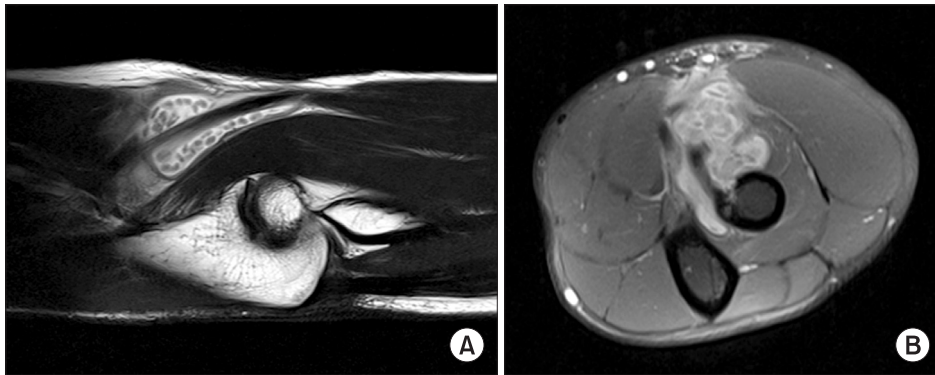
(A) The proton density-weighted sagittal image shows a mass surrounding the biceps tendon that extends to the distal part of the radial tuberosity. (B) The T2-weighted axial image shows multiple low signal rice bodies within the mass lesion.
